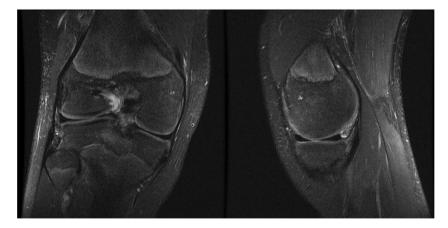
T2 sagittal and coronal MRI images of a 16-year-old female 2 years s/p transphyseal ACL reconstruction with graft retear. MRI images demonstrate presence of lateral hemi-joint bone bruising
